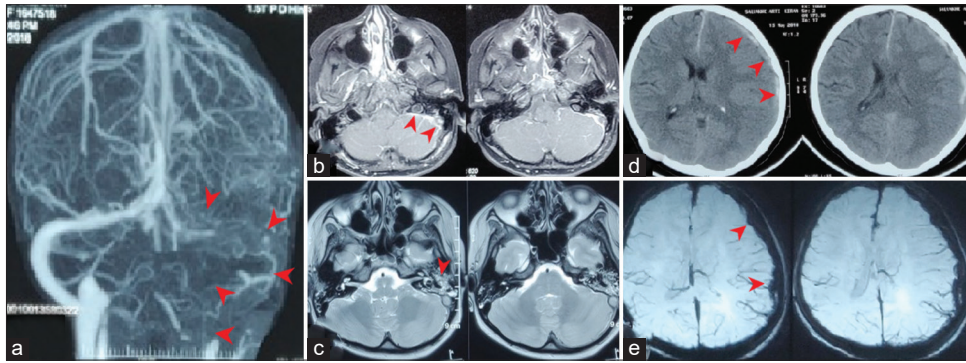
Primary imaging findings. (a) MRI contrast venography shows complete occlusion of the left transverse, sigmoid sinuses, and internal jugular vein. (b) Contrast-enhanced T1 MRI shows filling defects in the left transverse and sigmoid sinuses with adjacent dural enhancement. (c) T2-weighted MRI shows collection in the mastoid sinus and middle ear adjacent to the thrombosed sinus. (d) CT appearance of the left frontotemporoparietal subdural hematoma (SDH) as a complication of anticoagulant medication. (e) MRI SWI showing left frontotemporoparietal SDH
